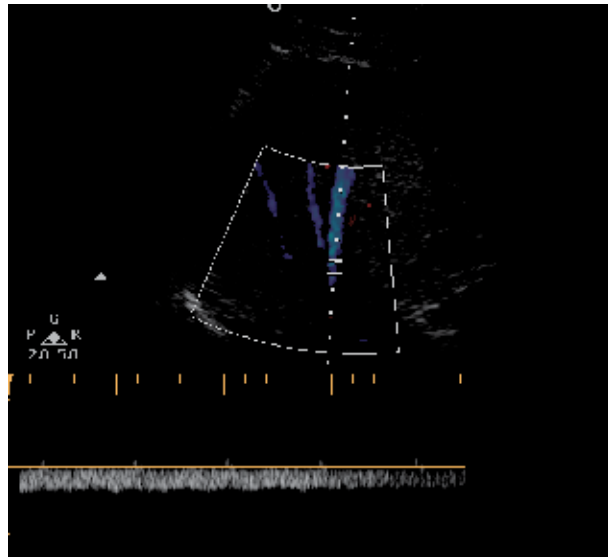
Monophasic VHDx Doppler waveform in 53 y.o. patient with moderate severity of liver fibrosis (Knodell F-3) and severe mixed type (macro - microvesiculare) steatosis (S3). There are no typical steatosis signs in B- mode image
